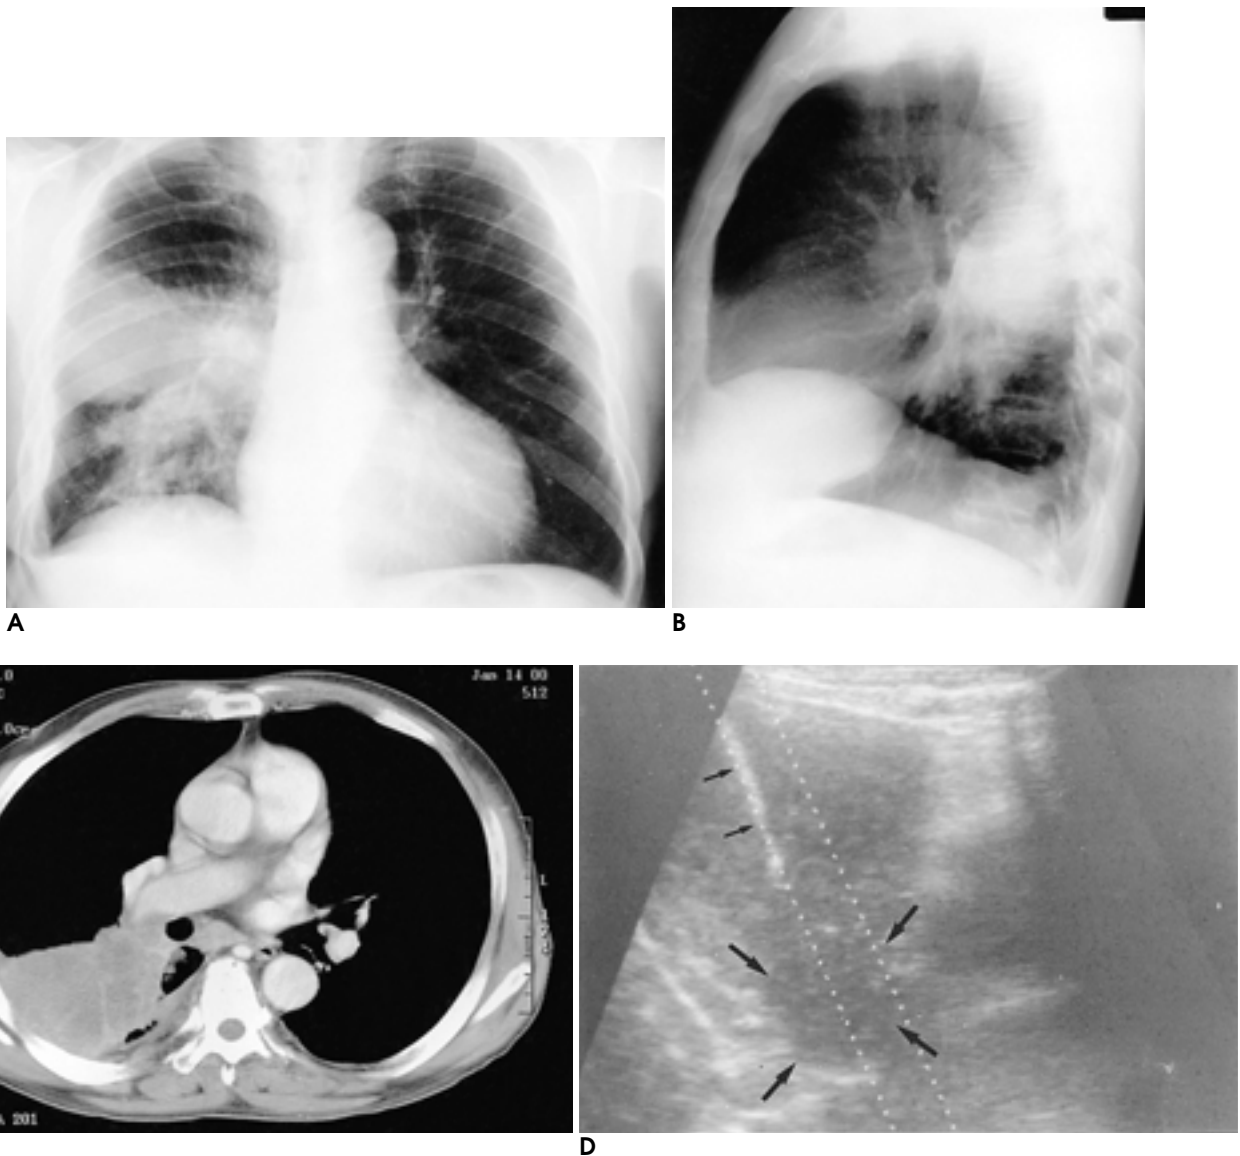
Isoechoic lung mass in transthoracic needle biopsy.
